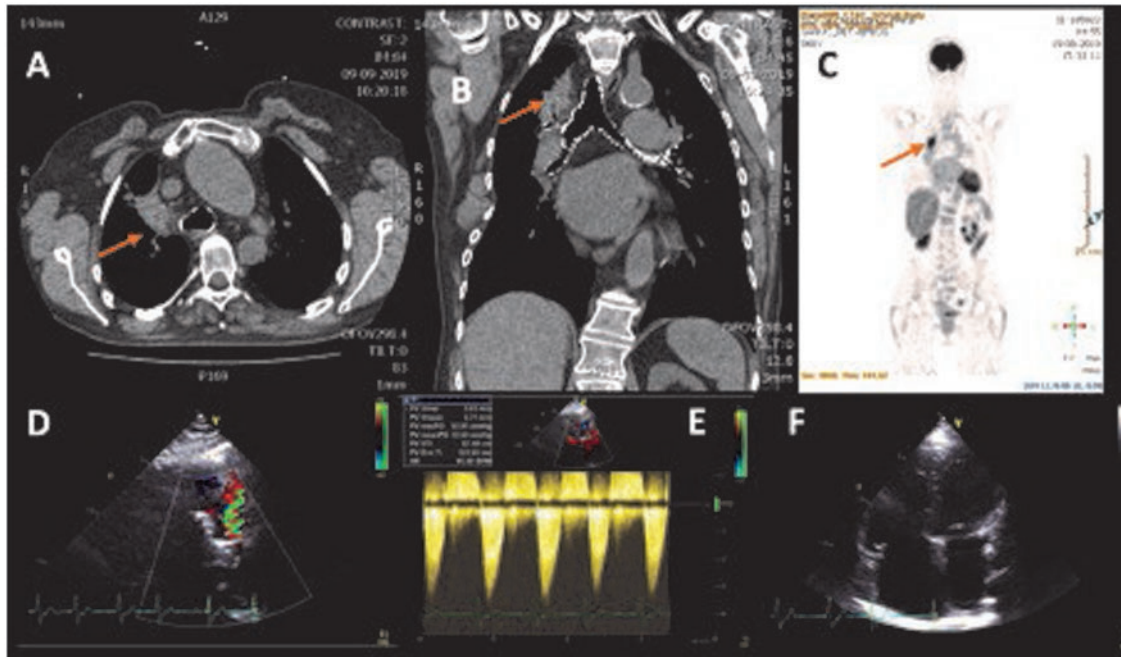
Positron emission tomography–computed tomography (A–C) showing axial and coronal planes. The orange arrow indicates the stellate nodule with isotope accumulation in the right upper lung lobe. Transthoracic echocardiography (D–F) with parasternal short-axis view (D), continuous wave velocity over the pulmonary valve (E), and apical four-chamber view (F). Colour Doppler flow indicates regurgitant flow in diastole, indicating pulmonary valve regurgitation. Continuous wave velocity indicates a peak/mean gradient in systole across the pulmonary of 53/32 mmHg indicating pulmonary valve stenosis.
